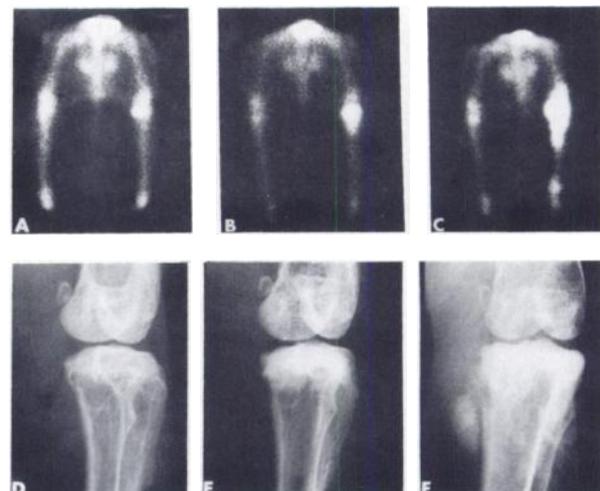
Well-differentiated osteosarcoma developing in left hind leg after irradiation with 4650 rad fractionated over 3 wk. Supine TcPPi images at 9.5 (A), 12 (B), and 14.5 (C) mo, and radiographs at 9 (D), 12 (E), and 14.5 (F) mo after irradiation. Tumor first seen on images at 9.5 mo (A) by focal increase of TcPPi in proximal tibia and subsequently on radiographs at 12 mo (E) as osteoblastic lesion in same location. Progression of tumor growth is evident on later images and radiographs.
